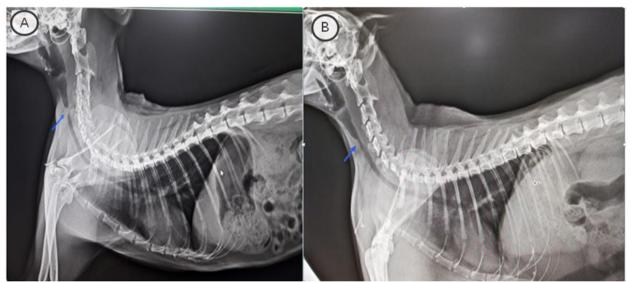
A. X-ray before the first operation, the mass indicated by arrow. B. X-ray taken when the patient was brought to our clinic, the appearance of the recurrent mass was observed in the same area.
